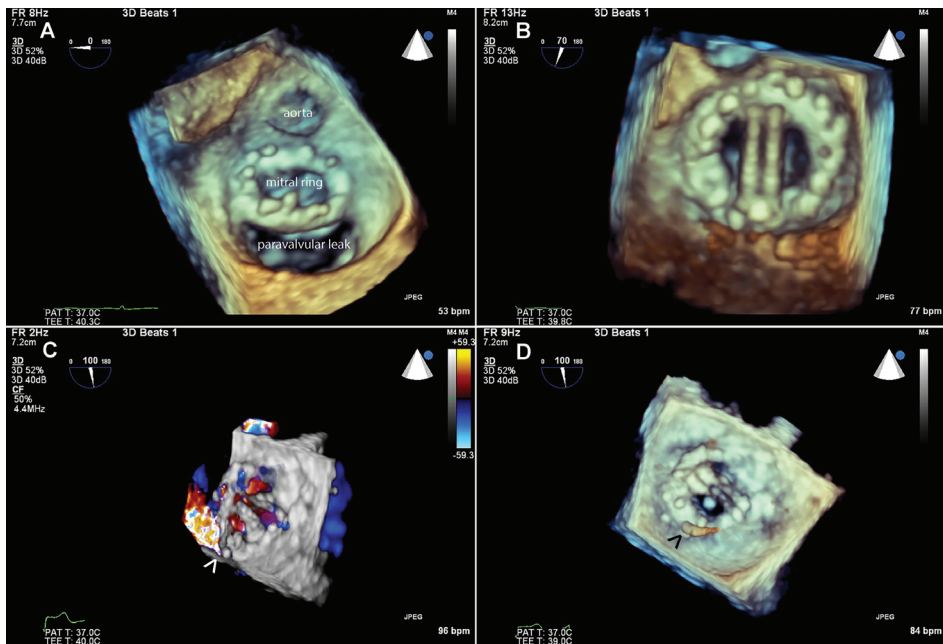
Three-dimensional echocardiography showing mitral ring dehiscence (A) and replacement with a mechanical prosthesis (B). In the lower panel shows localization of smaller paravalvular leakage after implantation of a mechanical prosthesis by the origin of the 3D color Doppler jet (C, arrowhead), facilitating wire passage (D, arrowhead) and thus placement of a closure device.
